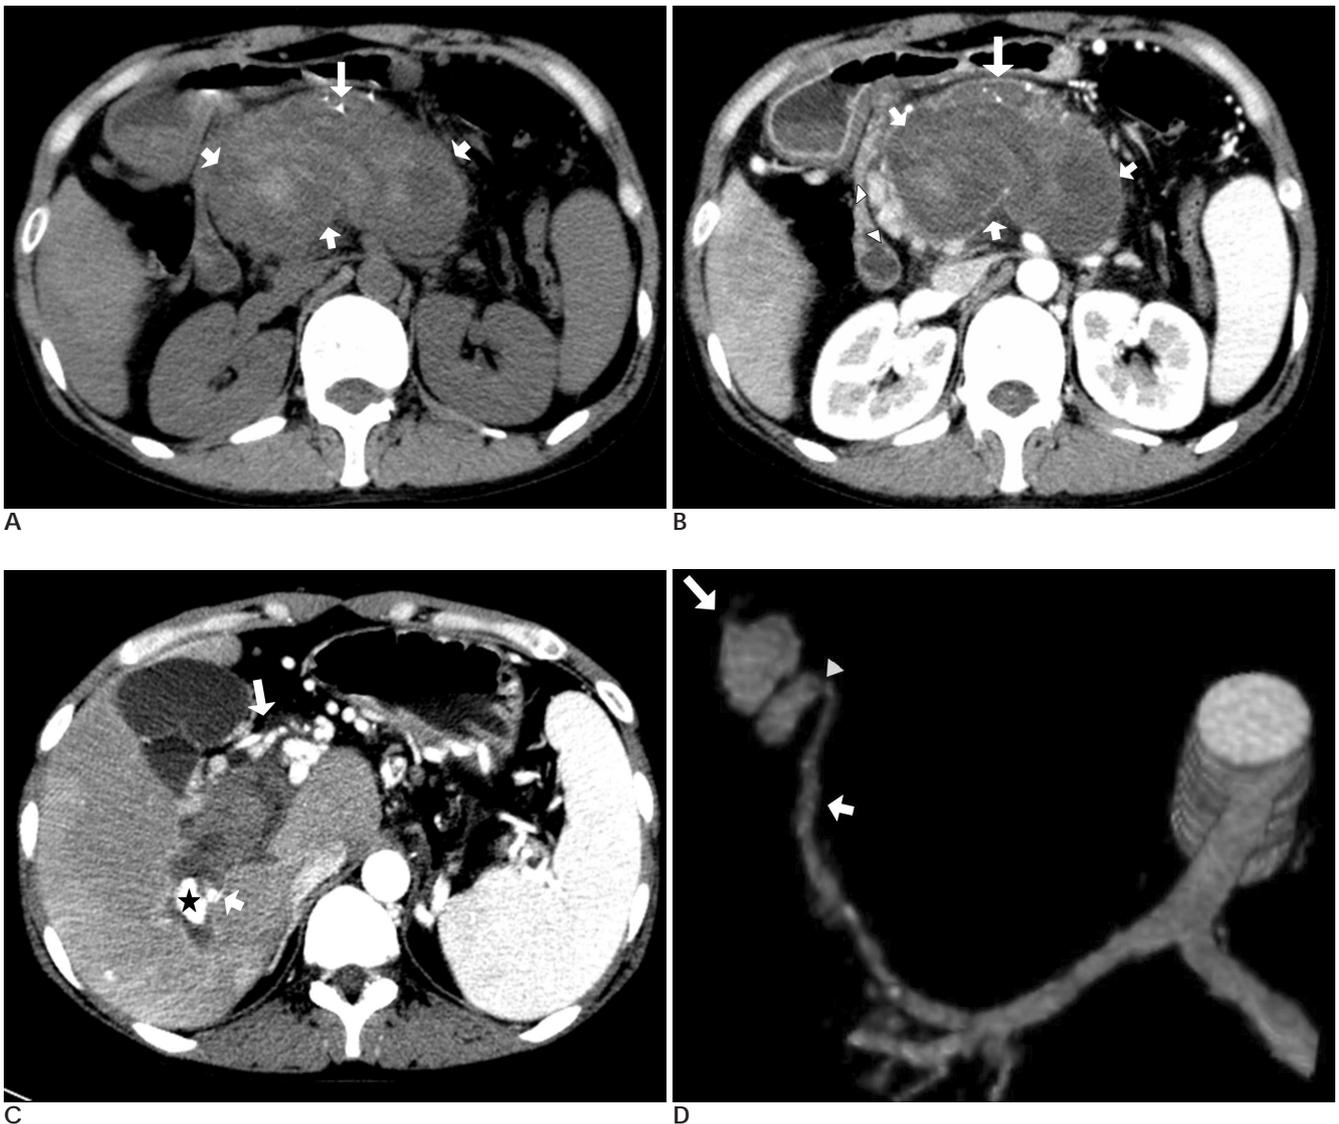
A. The unenhanced axial CT scan reveals the intraductal stones (long arrow) in the pancreatic body and a high density thrombosis at the portal-splenic vein (short arrows). B. The arterial phase CT scan shows the decreased pancreatic volume and duct dilatation, representing chronic pancreatitis (long arrow). The axial CT reveals thrombosis (short arrows) at the portal-splenic vein with collateral vessels (arrowheads). C. An approximately 1.5 cm well-enhanced nodular lesion (asterisk) is observed within the thrombosed right posterior portal vein with collateral vessels (long arrows) on an arterial phase CT scan. This lesion originated from the right hepatic artery (short arrow), which suggests a hepatic artery pseudoaneurysm. D. A three-dimensional volume rendering CT image shows the pseudoaneurysm (long arrow), which developed from the right hepatic artery (short arrow). The neck portion (arrowhead) of the pseudoaneurysm had a diameter of 1 mm.
